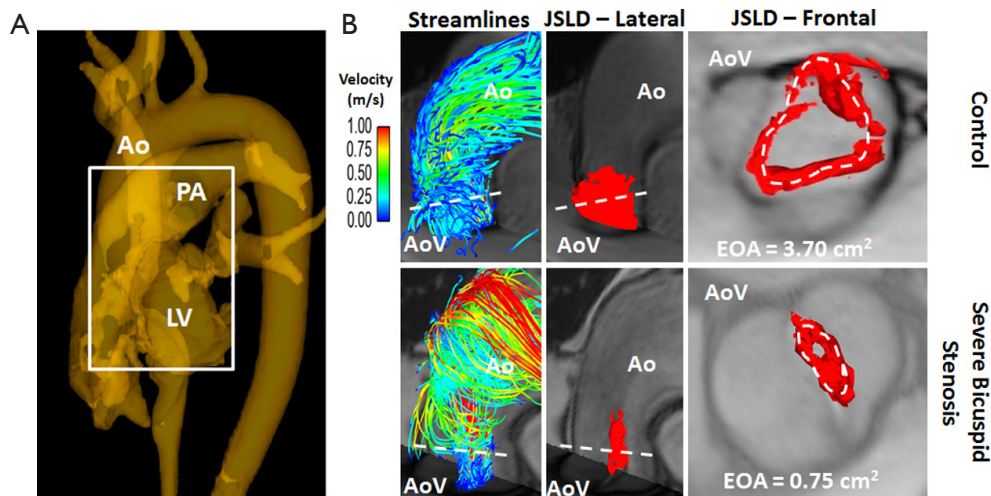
Aortic valve EOA estimation with the 4D flow jet shear layer detection method. (A) 3D PC-MRA based on 4D flow data. The white box delimits the volume for EOA assessment; (B) EOA estimation of a control subject (top row, $EOA = 3.70 \text{ cm}^2$) and a patient with severe bicuspid stenosis (bottom row, $EOA = 0.75 \text{ cm}^2$). 3D streamlines at peak systole indicate substantially different ascending aortic flow patterns for both subjects. The structures (red surfaces) result from flow JSLD computed from 4D flow MRI data at peak systole which can be employed to quantify changes in the aortic valve EOA, i.e., valve stenosis severity. The dashed white line indicates transvalvular maximal velocity position. Ao, aorta; AoV, aortic valve; LV, left ventricle; EOA, effective orifice area; JSLD, jet shear layer detection.
